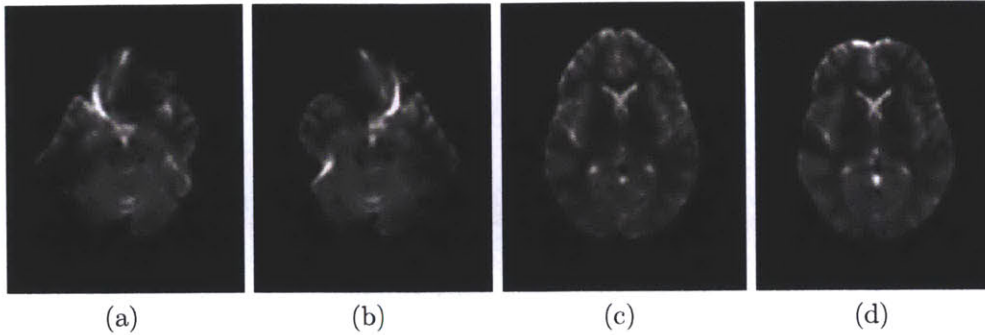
DWI Data from a single subject in the DTI distortion correction study. Diffusion weighted images of a single subject with R/L phase encoding (a,b) and A/P phase encoding (c,d).
